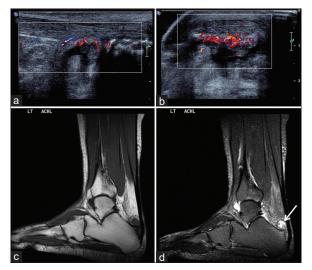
Magnetic resonance imaging (MRI) and ultrasound (US) findings of Achilles enthesopathy in a patient confirmed to have axial spondyloarthritis. Longitudinal (a) and transverse (b) US section through the Achilles tendon demonstrating abnormal vascularization of the cortical bone insertion on power Doppler imaging. The corresponding MRI [T1W sagittal (c) and short tau inversion recovery (d) sequences] demonstrates fluid in the bursa (white arrow) and surrounding edema and inflammation. Note the inflammation in the different fibrocartilage areas as previously discussed in Figure 1. Cortical irregularity, erosions, and bilaterally are also other pertinent findings to help differentiate from isolated Achilles tendinitis and consider spondyloarthritis as an underlying
